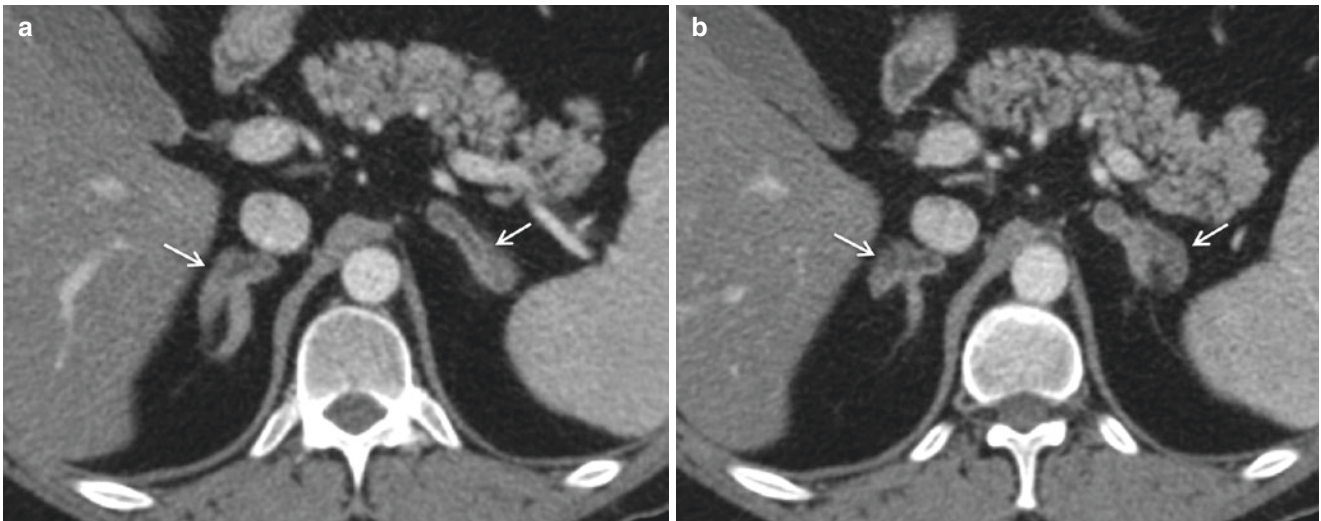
ACTH-dependent Cushing's syndrome. Post-contrast CT images with diffuse enlargement of both adrenal glands (*white arrows*)
